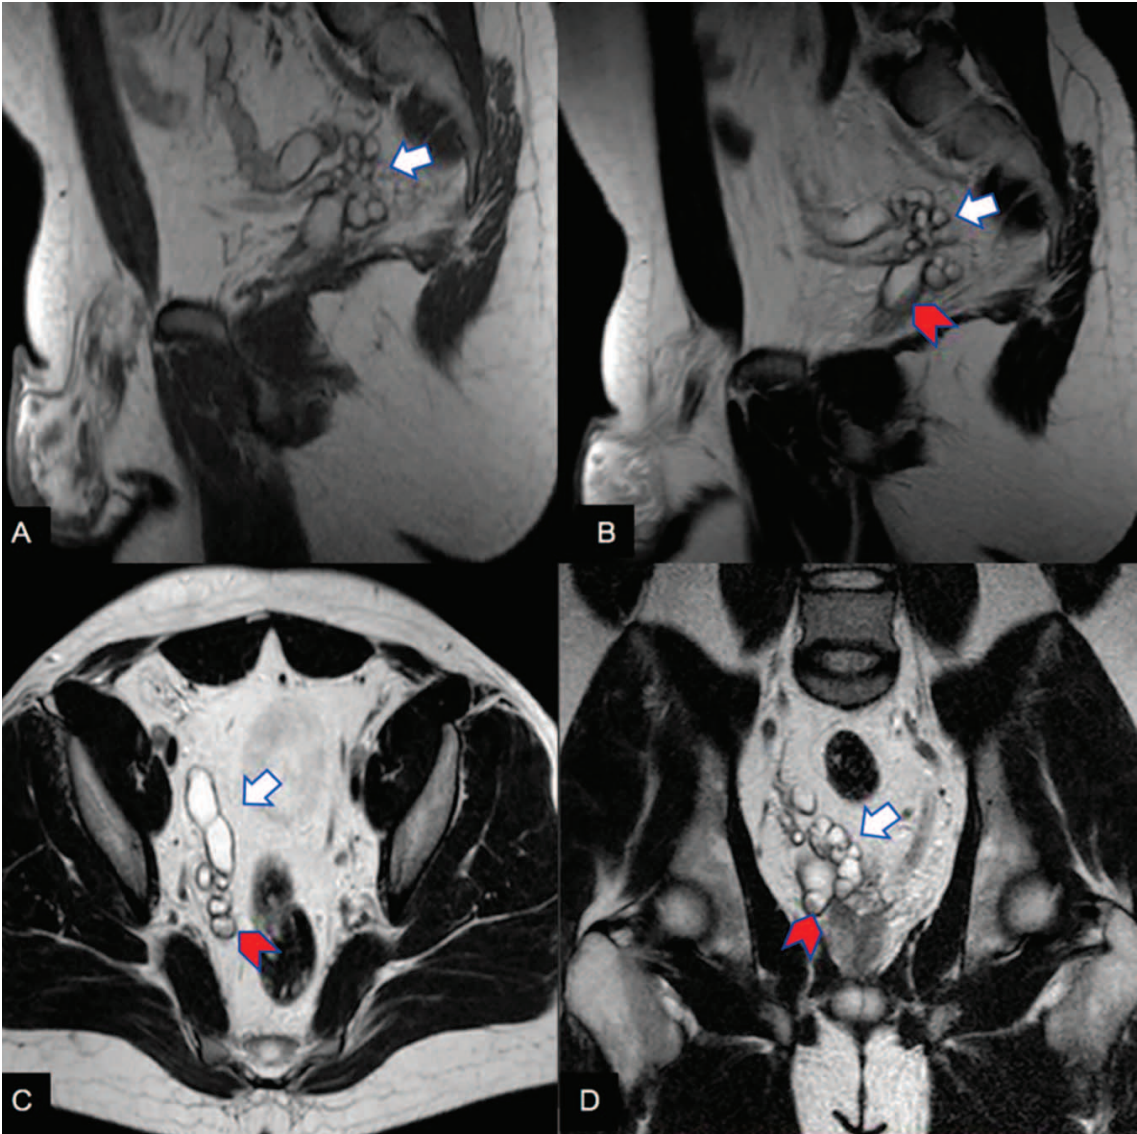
(A) Sagittal T1 MRI: cystic dilatation of the right seminal vesicles (white arrow), with hyperintense signal on T1, indicating proteinaceous component. (B, C, D) Sagittal, axial, coronal T2 MRI: cystic dilatation of the right seminal vesicles (white arrow), with fluid levels in some of them (red arrow) located close to each other, extending caudally into the spermatic cord
